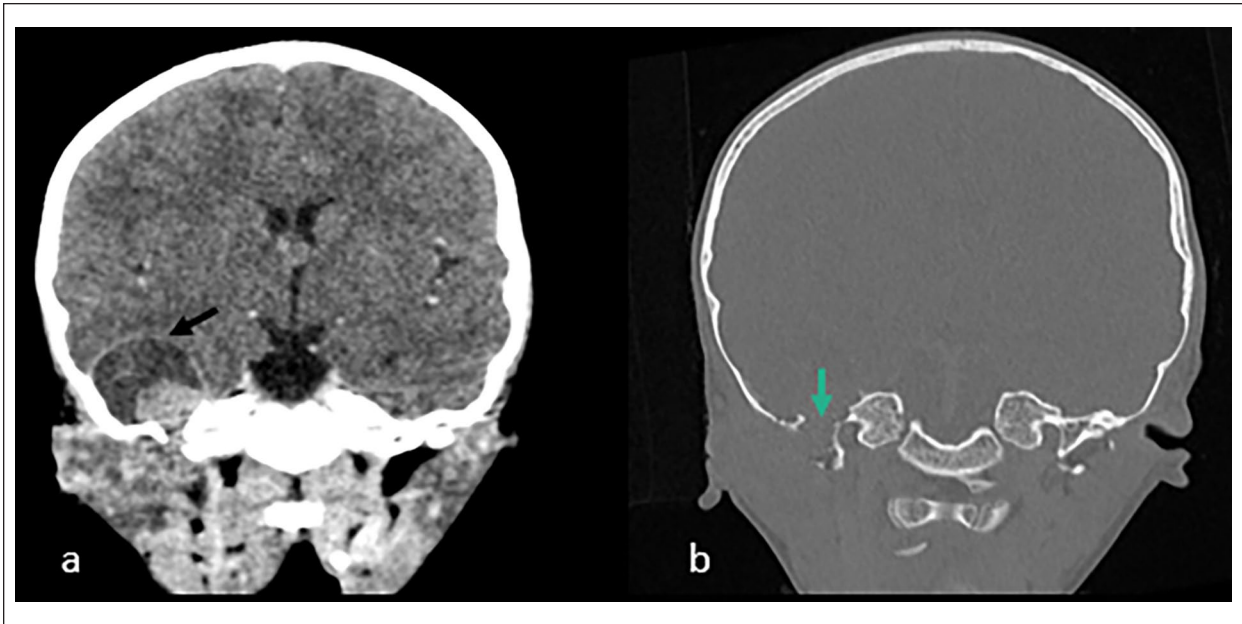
CT images at the time of presentation: coronal reconstruction in the parenchymal window (a) and in the bone window (b) showing the intracranial extension of the tumor (black arrow) with bone lysis (blue arrow).
